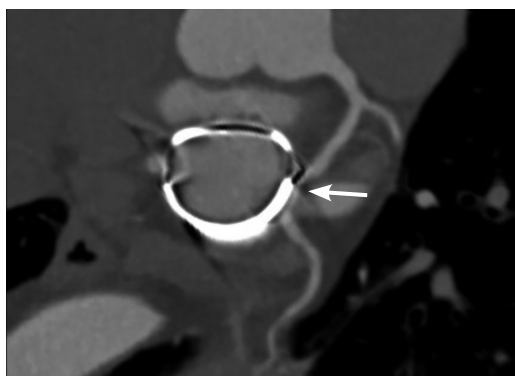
Coronary computed tomography angiography of the Circumflex Artery (CxA). Extrinsic stenosis of 90% at the middle third of the CxA, close to the annuloplasty ring (white arrow).
